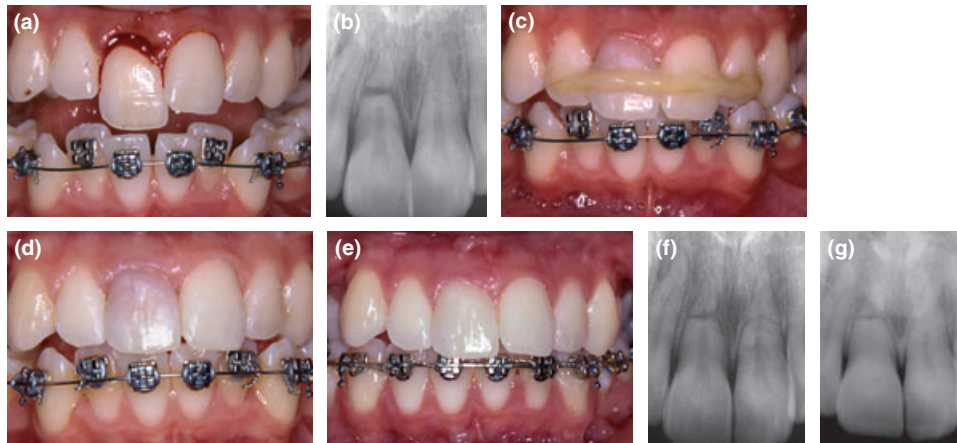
A 15-year-old girl, who 3 days before received a blow against her mouth. The right upper incisor had had an intra-alveolar root fracture before which had healed with connective tissue. (a, b) Clinical photograph and radiograph 3 days after injury showing extrusion of the coronal fragment in 11 and an intra-alveolar without dislocation in 21. (c) Discoloration in 11 2.5 weeks after injury. (d) 2 months after injury, the discoloration is still obvious. (e, f) 1 year and 6 months after injury, 11 have regained its normal colour. Both incisors have a negligible increased mobility and normal sensibility and have healed with connective tissue. Internal tunnelling resorption can be seen in 21. (g) Control 9 years after injury. Obliteration is seen in 11. The resorption process is arrested in 21, and obliteration in the coronal pulp canal can be seen. Courtesy Dr Maria Andersson.
